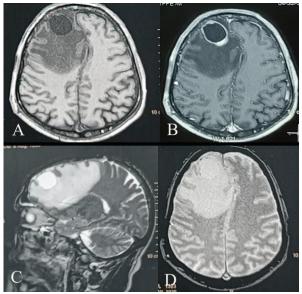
Brain MRI showing a double component mass cystic and fleshy, iso signal in T1WI (A), with contrast enhancement (B), the cystic component hyper signal in T2WI (C), with no hemorrhagic signal (D)
